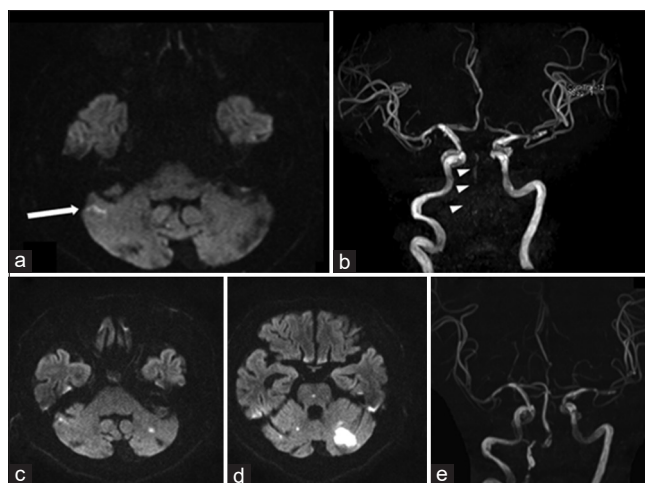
Initial brain magnetic resonance image revealed tiny acute infarction in the right cerebellum on the day of admission (arrow) (a) and severe stenooclusion throughout the whole vertebrobasilar artery system (white arrowhead) (b). Follow-up diffusion-weighted images (DWI) on the hospital day 5 showed extension of preexisting acute infarction in the right cerebellum (c) and additional new acute infarctions in both cerebellar hemispheres and pons (d). Follow-up magnetic resonance angiography at 1 year after admission demonstrated much-improved patency of vertebrobasilar vasculature (e)
